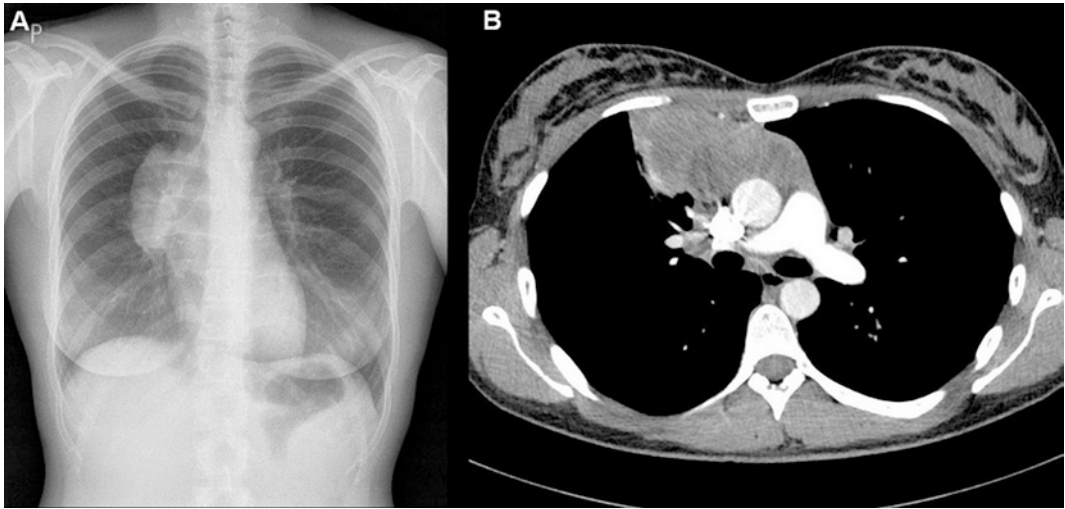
Stage IV thymic carcinoma in a 60-year old patient. Contrast-enhanced CT showing heterogenous mass in the anterior mediastinum with left pleural effusion and left pleural metastasis
